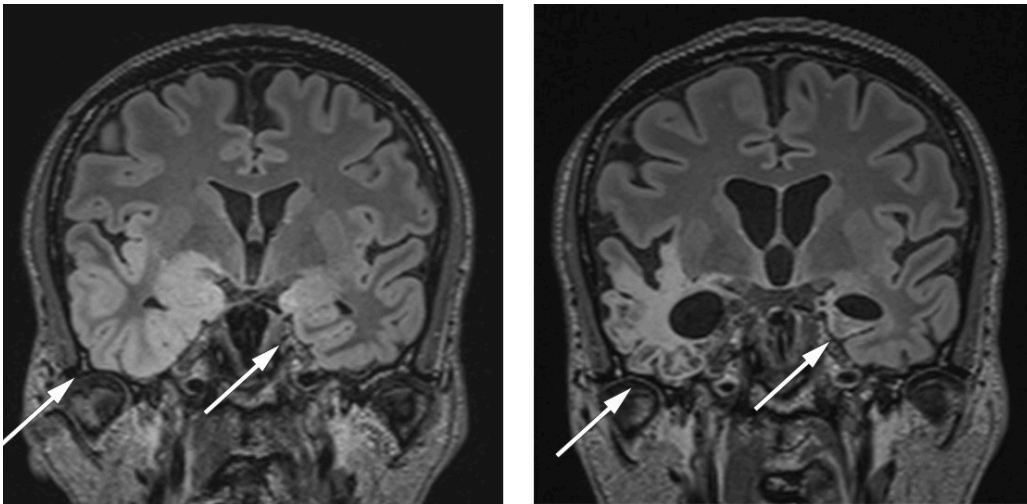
MRI with coronal T2-weighted FLAIR sequences. a) Six days after the first admission, hyperintense cortical thickening can be seen in both temporal lobes. b) Four and a half months after the first scan, significant loss of brain tissue can be seen in the previously encephalitic areas.
